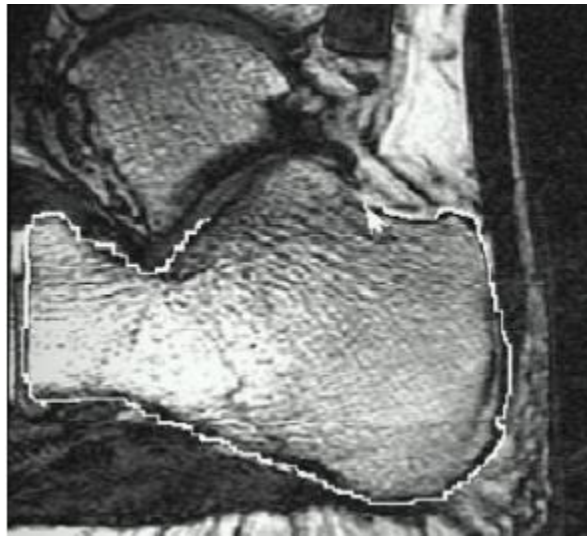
MRI scan being analyzed and segmented to create 3-D model[14].
